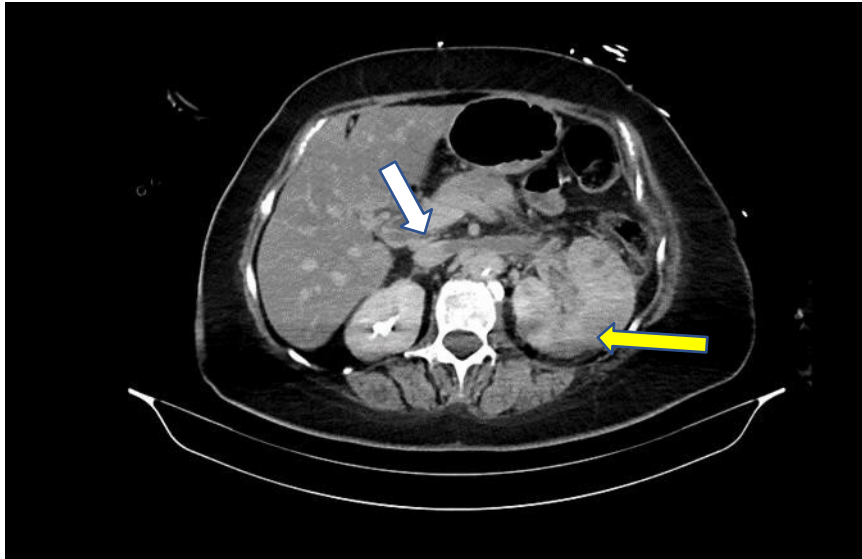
Abdominal CT. Enlarged left kidney with diffuse nephritis areas along some abscessed areas (yellow arrow), with thrombosis of the left renal vein that extends to the vena cava (white arrow).
